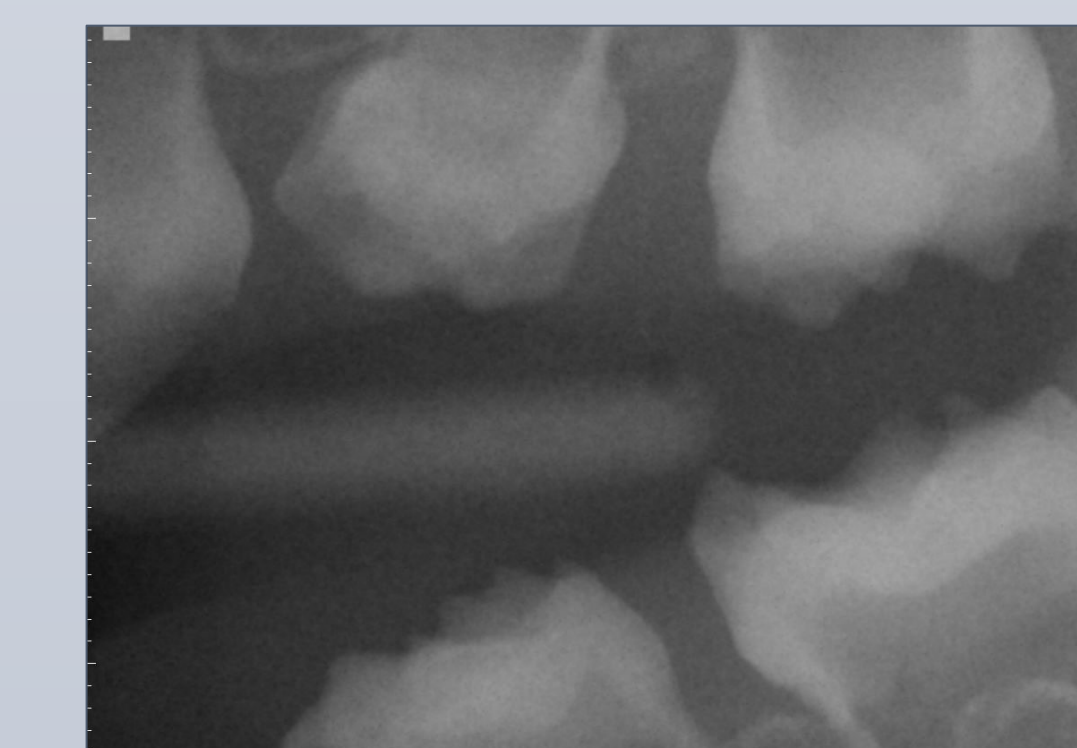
Left Bitewing 12/21/2016
